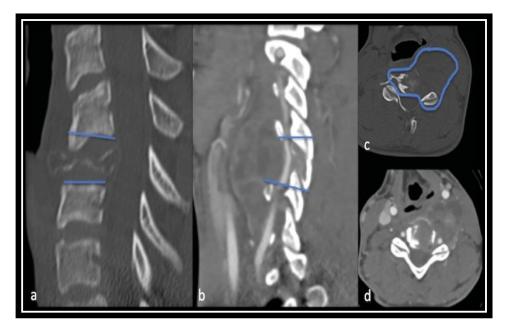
Aneurysmal bone cyst. Sagittal computed tomography (CT) (bone windows) (A), sagittal CT angiogram (B), axial CT angiogram bone window (C), and soft tissue window (D) showing site of resection (bluelines). The left vertebral artery and left C6 nerveroot need to be resected. (We instein-Boriani-Biagini 2–9, a-c).
